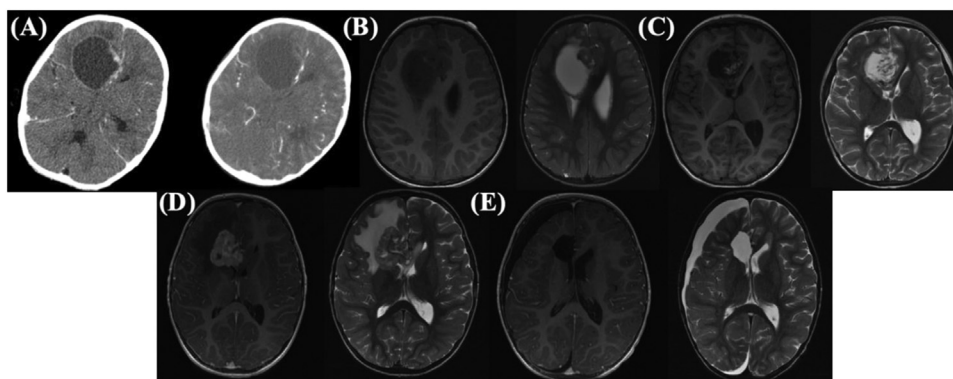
(A) Preoperative axial computed tomography at initial diagnosis showing a large cystic lesion in the right frontal lobe measuring approximately $5.4 \times 4.7 \times 4.6$ cm. (B) Preoperative brain MRI T1-weighted (left) and T2-weighted (right) showing a $2.0 \times 1.3 \times 1.5$ -cm cystic mass with peripheral solid enhancement within the right frontal lobe. (C) Postoperative axial MRI showing a right frontal craniotomy with slightly decreased mass effect and persisting findings of early/mild trapping of the left lateral ventricle with transependymal cerebrospinal fluid regression. (D) MRI showing the interval development of a $3.3 \times 3.2 \times 3.2$ -cm heterogeneously enhancing solid mass within the medial right frontal lobe at the resection site, indicative of local recurrence. (E) Postoperative MRI of the right frontal lobe after excision. *Abbreviations:* MRI = magnetic resonance imaging.
